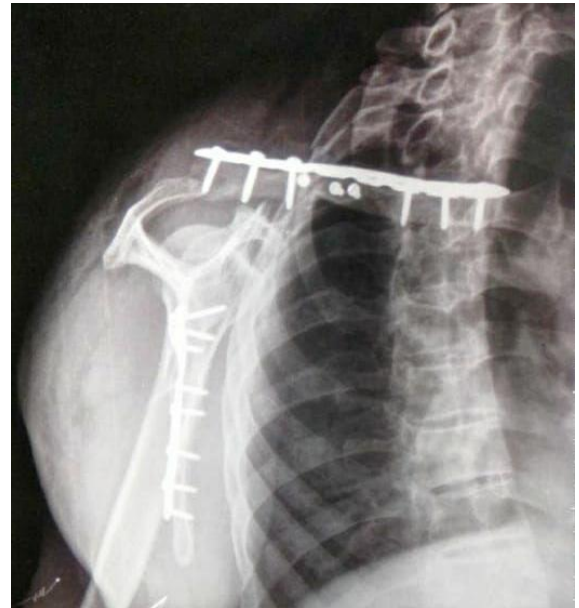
Case 2: Post-op X-ray Lat view (1 plates in Scapula, clavicle fixed with plate)
